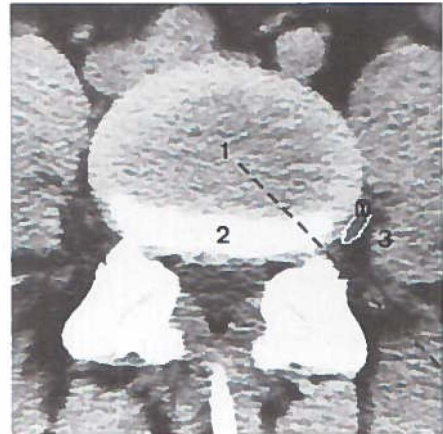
CT scan at a low level through disc L4-L5 and the superior endplate of the vertebra L5. Needle placement low in disc L4-L5 (represented by dotted line) clearly avoids the emerging L4 nerve root. 1. disc L4-L5; 2. superior endplate vertebra L5. 3. L4 nerve root outlined (Photograph: Dr. J.T. Wilmink, Department of Neuroradiology).
